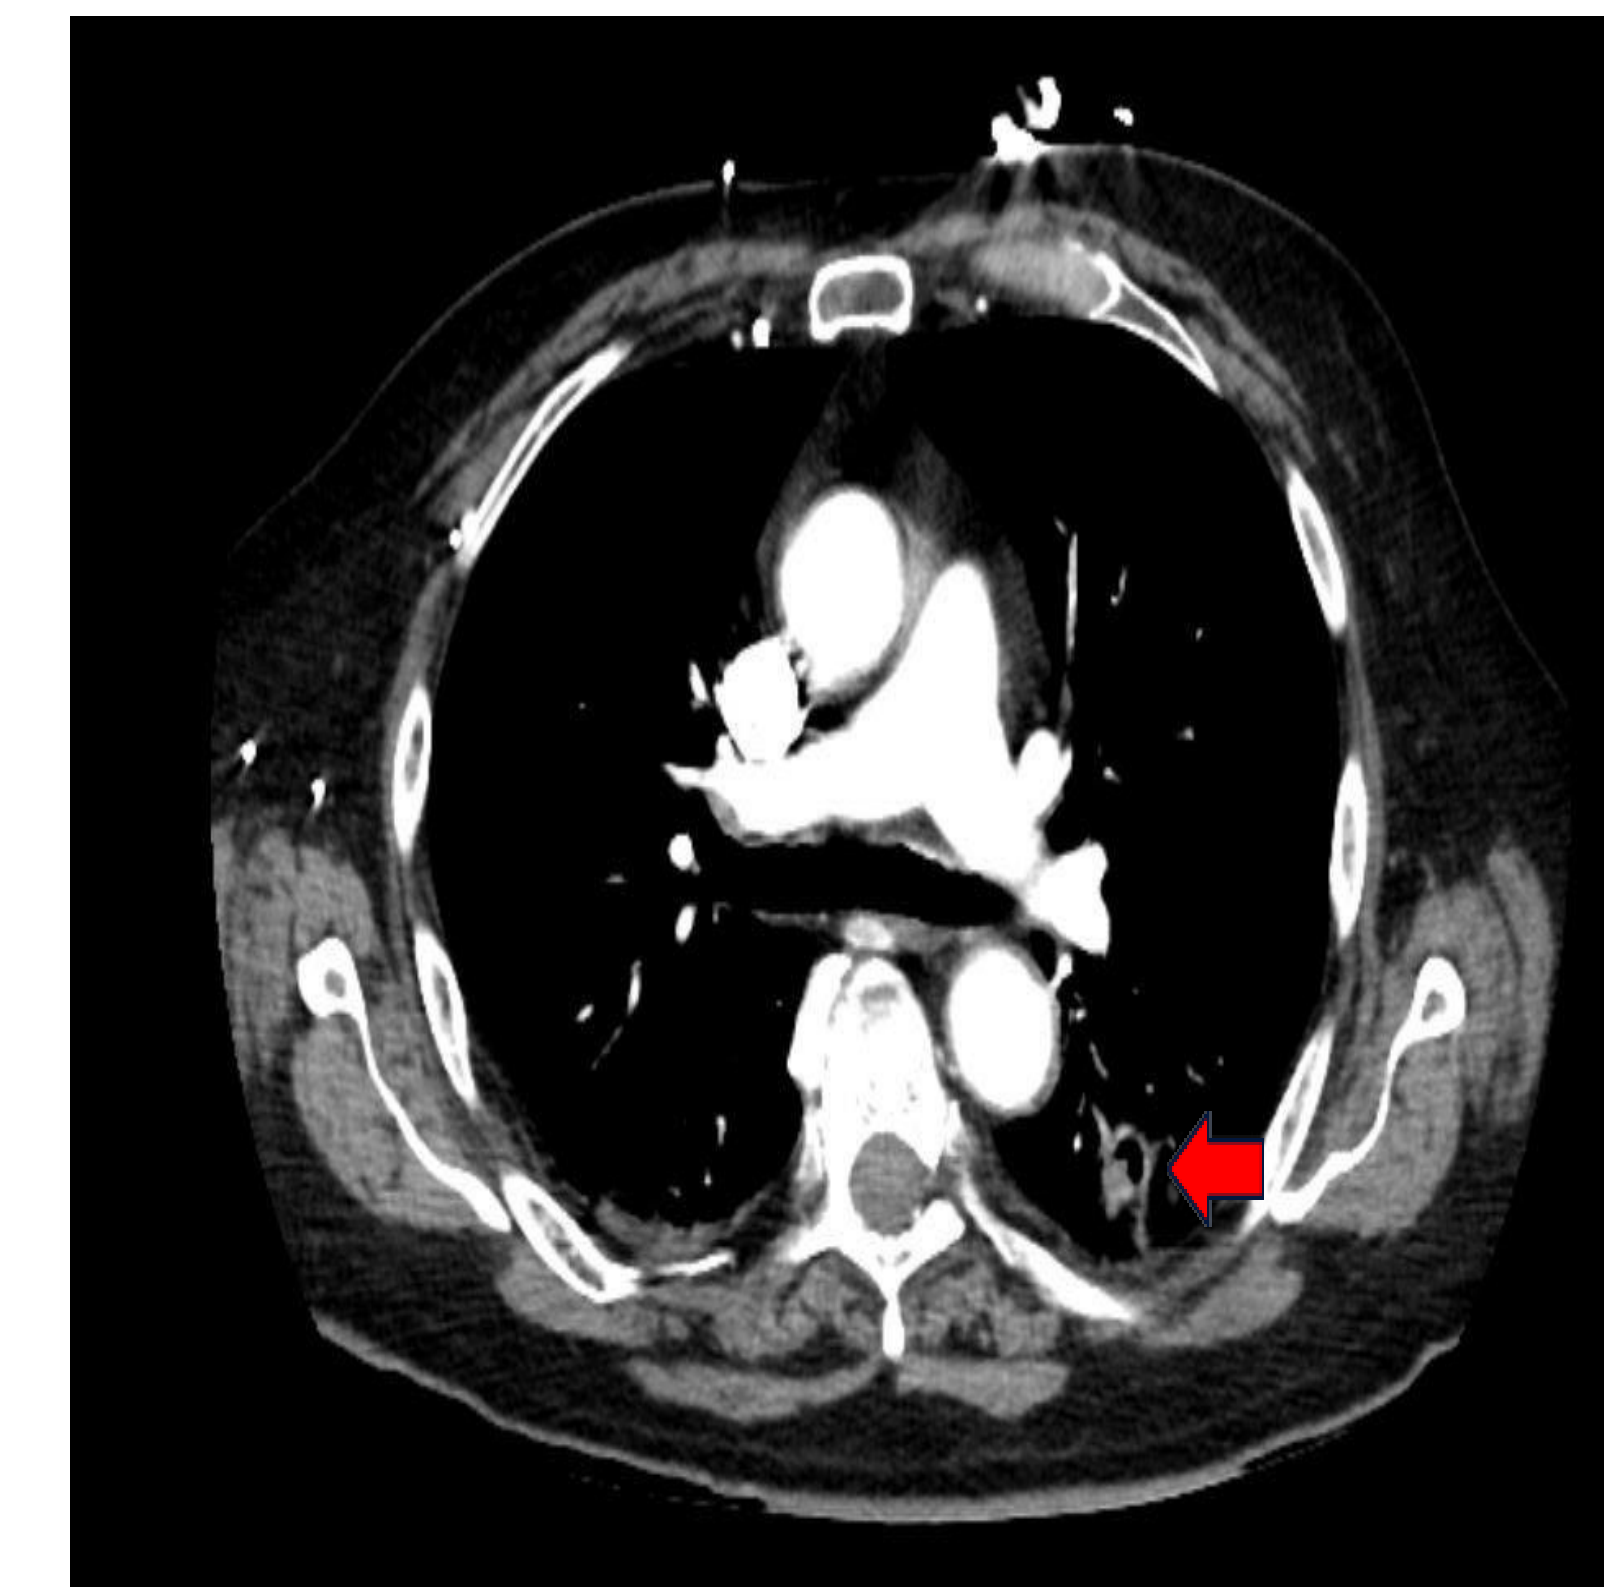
CT chest demonstrating small cavitory lesion in the left lower lobe (arrow).
